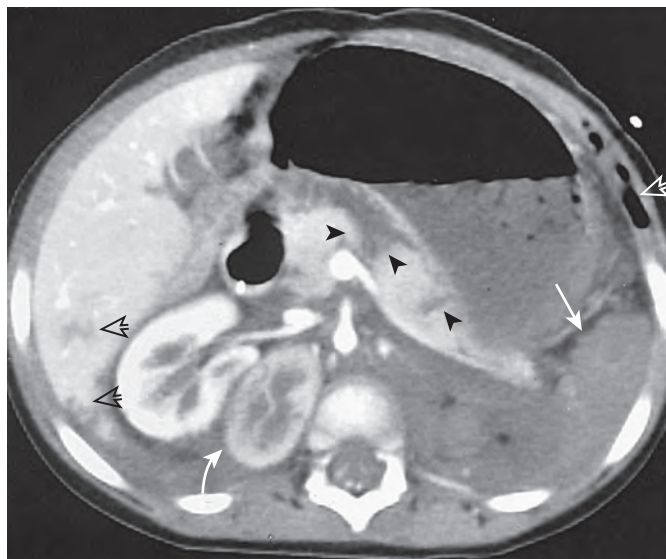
Pancreatic lacerations and multiorgan injury. A 16-month-old toddler was involved in a minivan accident. Contrast-enhanced CT demonstrates multiple pancreatic lacerations (black arrowheads), devitalized spleen (white arrow), a vascular injury of an ectopic unfused kidney (curved white arrow), right hepatic laceration (open black arrows), and subcutaneous emphysema (open white arrow) from a pneumothorax. The patient also had a spinal compression fracture. (Courtesy Andrew J. Fisher, MD, Mallinckrodt Institute of Radiology, St. Louis, Mo.)
